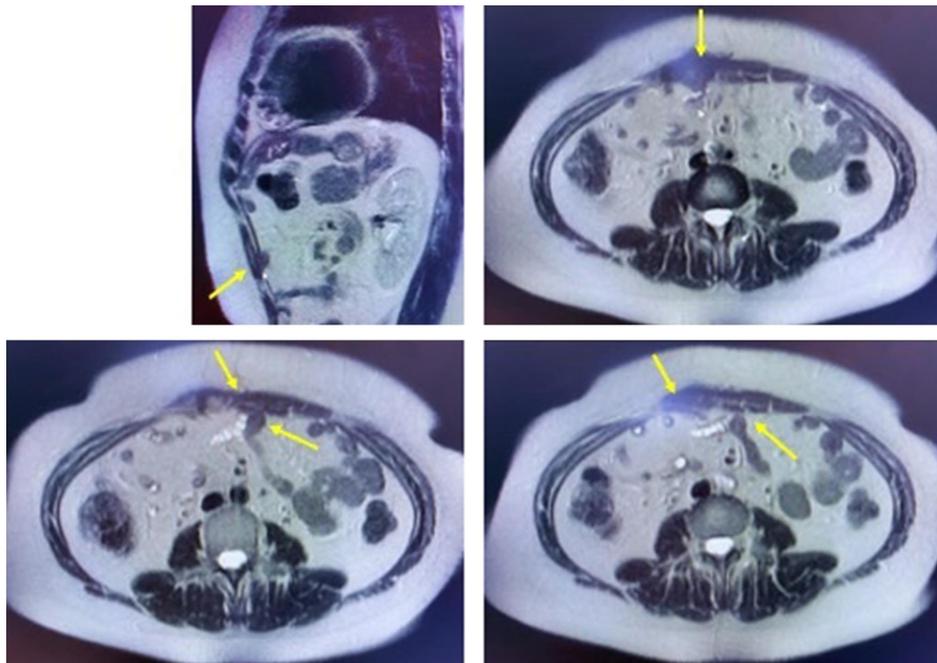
Images of the patient lesion by MRI. A localized lesion is observed in the abdominal wall, measuring 8 x 6 x 4 cm. The yellow arrows facilitate the identification of the focal point of the primary lesion, which involves the entire thickness of the wall and encompasses the anti-mesenteric margin of a jejunal loop.
